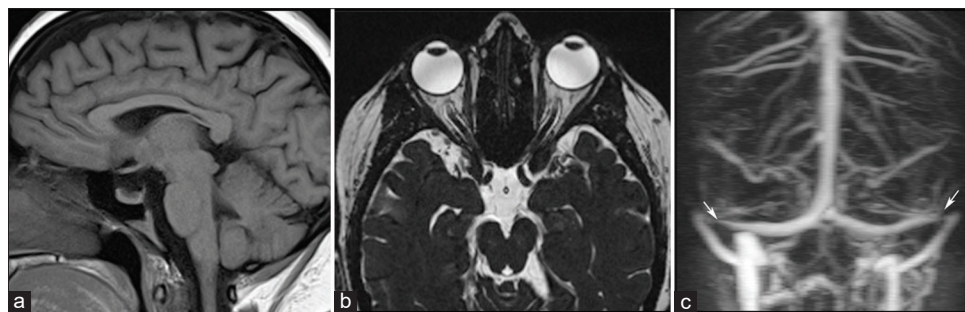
A 31-year-old female with intracranial hypertension. (a) Sagittal T1-weighted image shows empty sella (b) axial constructive interference in steady state image shows distension of bilateral optic nerve sheaths. (c) Coronal maximum intensity projection image of magnetic resonance venogram shows typical stenosis of transverse sinuses bilaterally (arrows).
